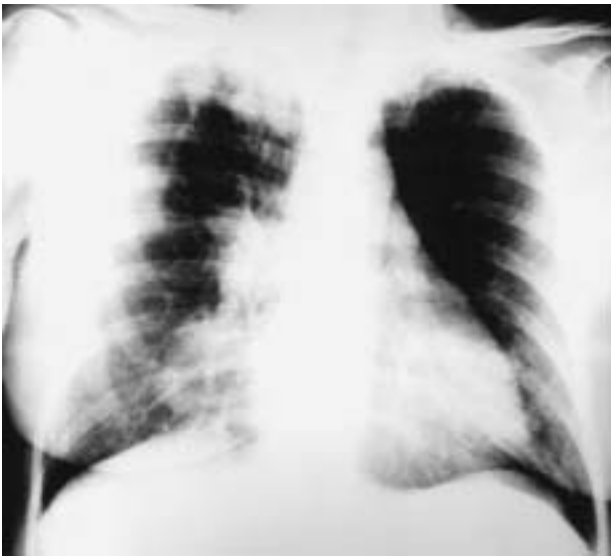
Posteroanterior chest x-ray in which an alveolar infiltrate in the upper right lobe and a lung nodule in the middle lobe can be seen.
